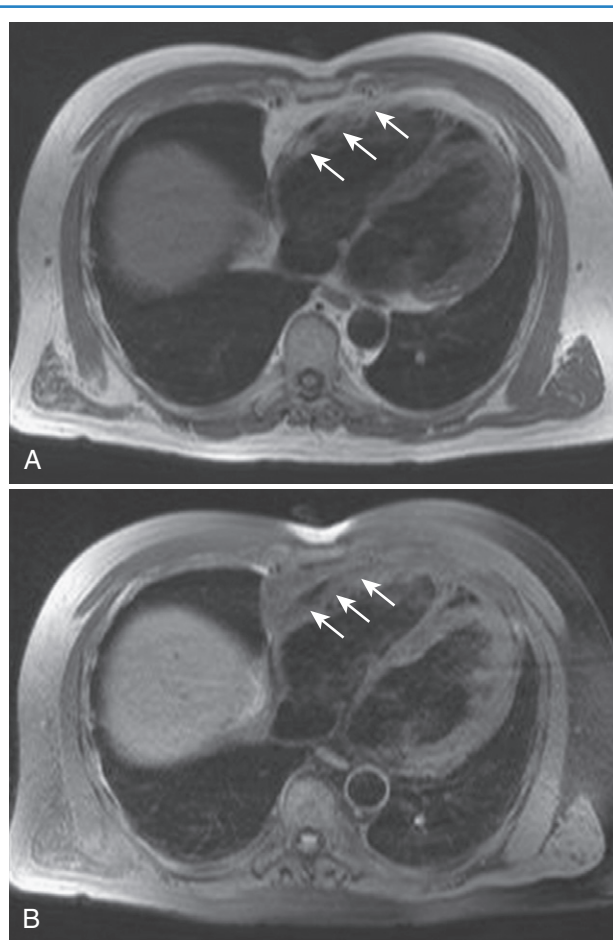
Arrhythmogenic right ventricular dysplasia. A, T1-weighted delayed enhancement magnetic resonance imaging demonstrating increased signal along the right ventricular free wall (arrows). B, Fat saturation imaging sequence confirms fatty infiltration along the right ventricular free wall (arrows). (Courtesy Dr. Jean Jeudy.)
